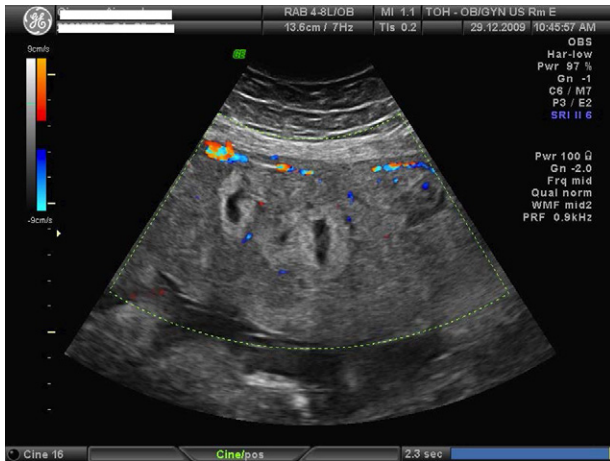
Transabdominal ultrasound image of the placenta at 32 weeks of gestation. The placenta appears heterogenous and bulky with multiple areas of infarction and poor vascular perfusion.
